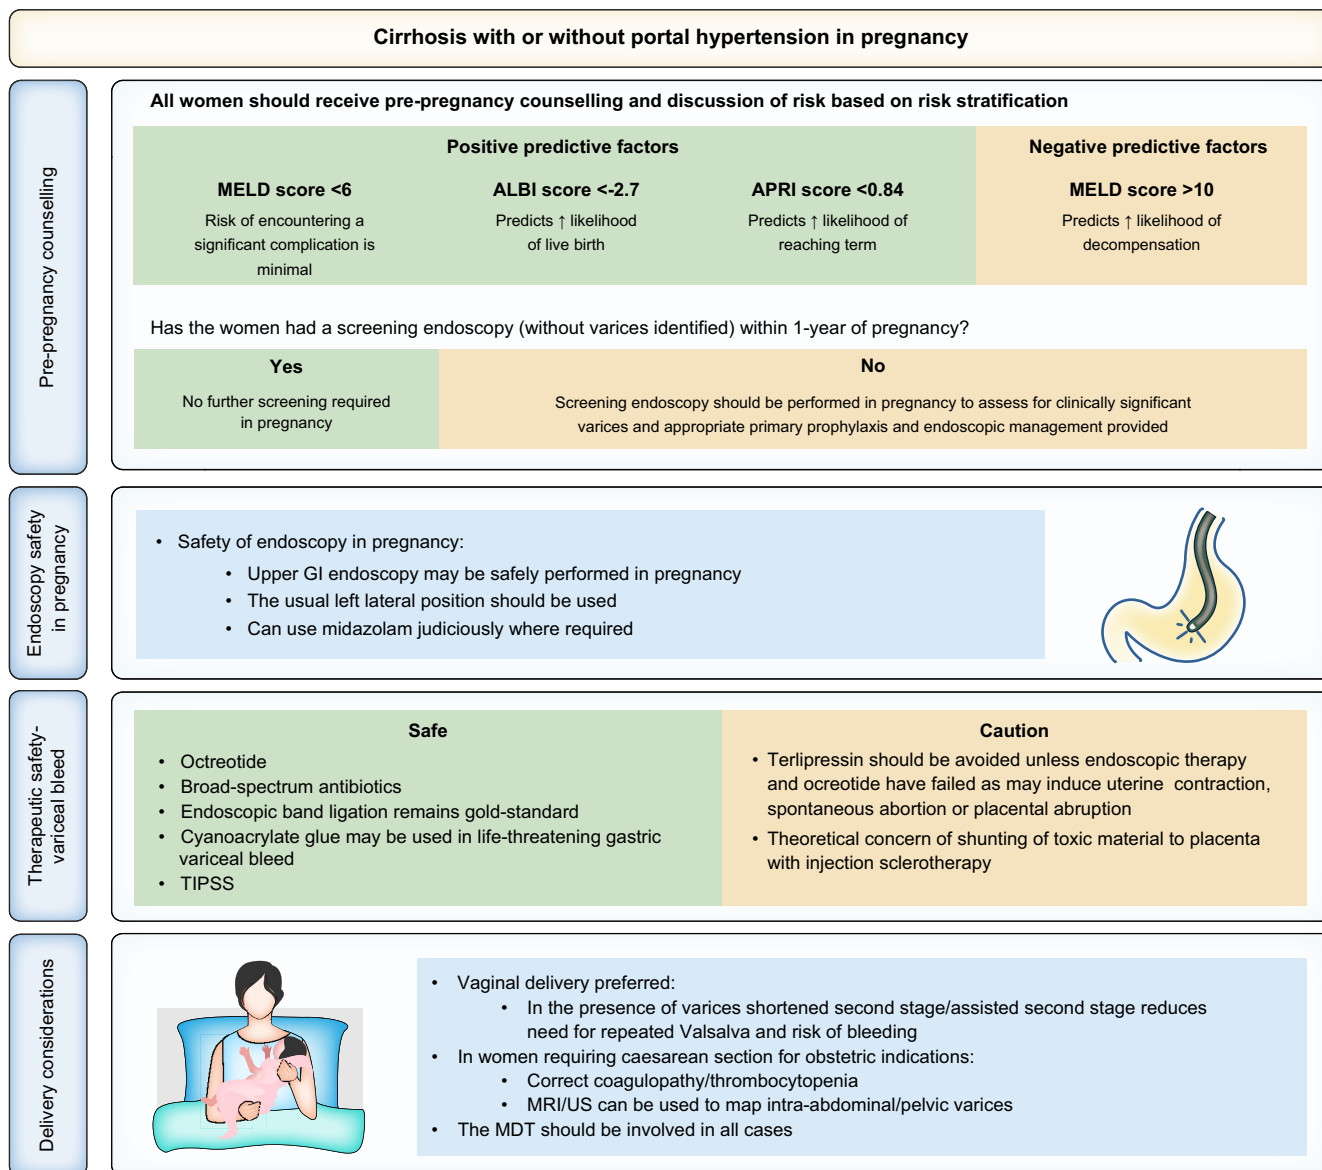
Cirrhosis with and without portal hypertension and pregnancy. ALBI, albumin-bilirubin; APRI, AST-to-platelet ratio index; GI, gastrointestinal; MELD, model for end-stage liver disease; TIPSS, transjugular intrahepatic portosystemic shunt; US, ultrasound.
